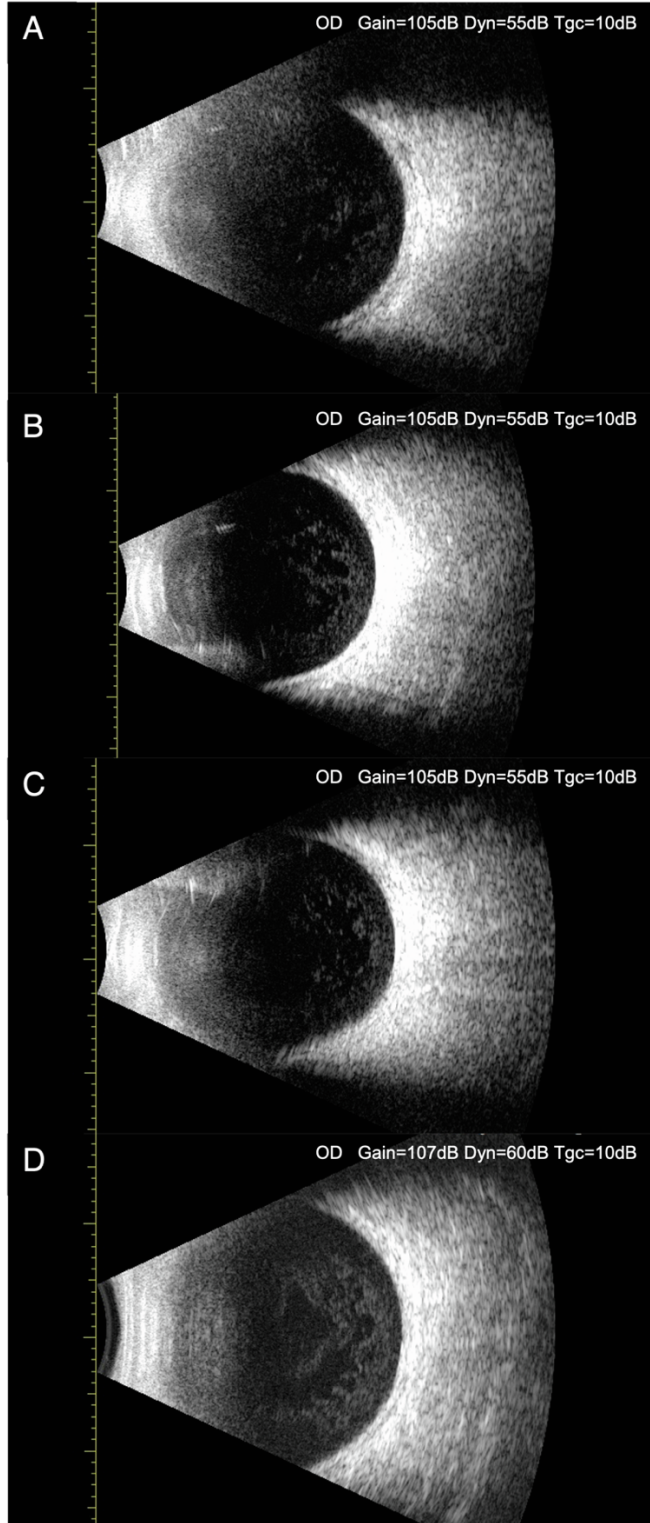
Postoperative B-scan ultrasonography of patient 1. B-scan ultrasonography of patient 1 on 7 days (A), 1 month (B), 6 months (C) and 12 months (D) post-injection revealed no remarkable changes in the vitreous body.
